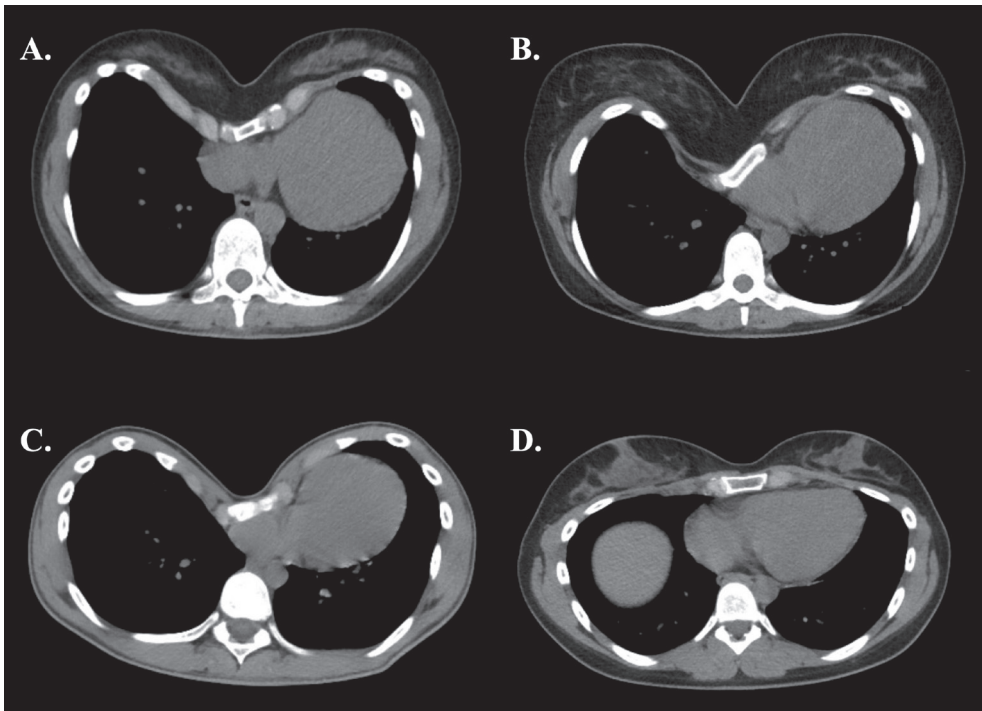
Transverse computed tomography slices of (A, B) two female patients with a relatively deep pectus excavatum, (C) a male patient with a deep deformity, and (D) a female patient with a shallow deformity.
